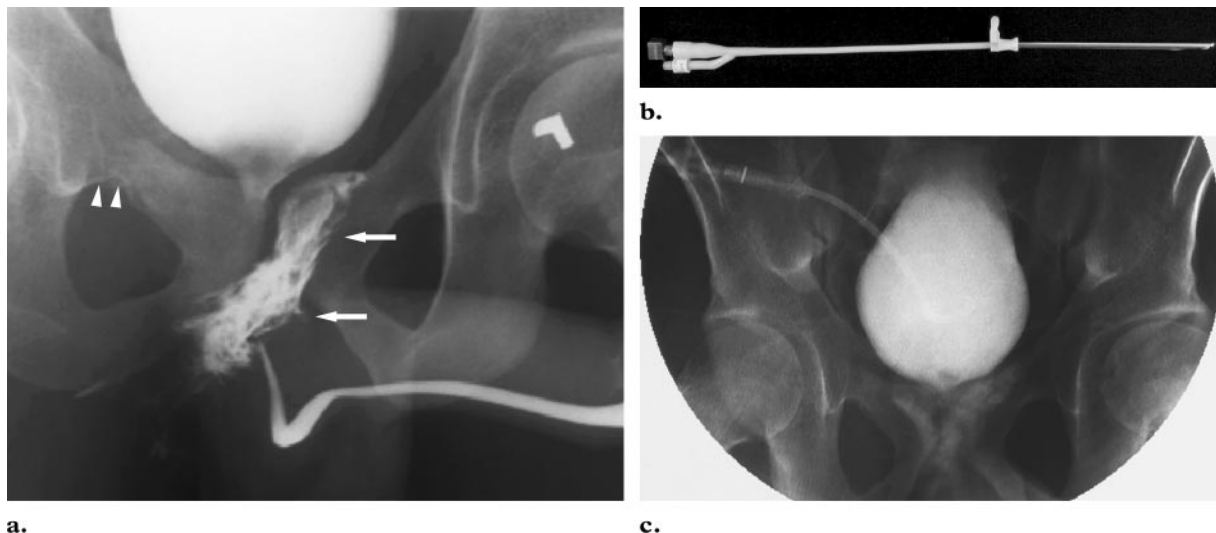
Type 3 urethral injury in an 18-year-old man who had sustained a crush injury to the pelvis. (a) Retrograde urethrogram shows contrast material extravasation above and below the urogenital diaphragm (arrows). Note the fracture of the right superior pubic ramus (arrowheads) and contrast material within the urinary bladder from prior contrast-enhanced CT. (b) Photograph demonstrates a regular Foley catheter (14-F suprapubic tube; Bard, Covington, Ga) loaded on a trocar-type introducing device for US-guided percutaneous placement. (c) Cystogram shows the suprapubic tube after US-guided placement.
